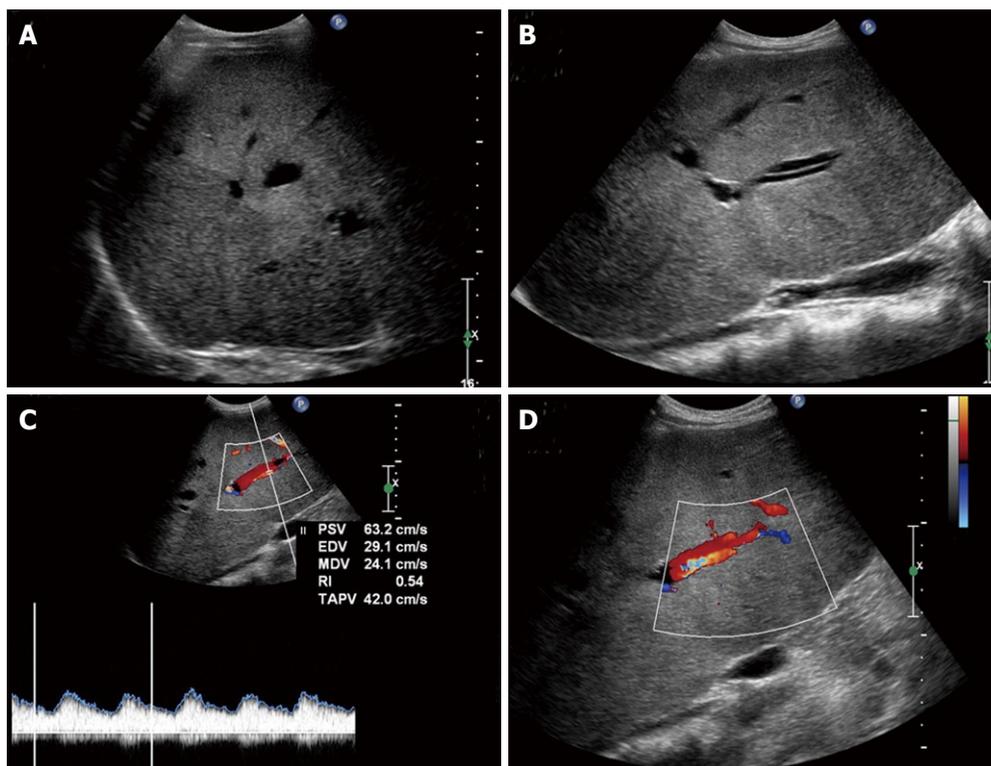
US scan showing a large hypoechoic area compared to surrounding parenchyma (A) and the image of "parallel channel" sign (B). Color-Doppler demonstrates the "pseudoparallel channel" sign, characterized by dilated intrahepatic arterial branch with an adjacent portal venous tract, and the low hepatic artery RI (C, D).
